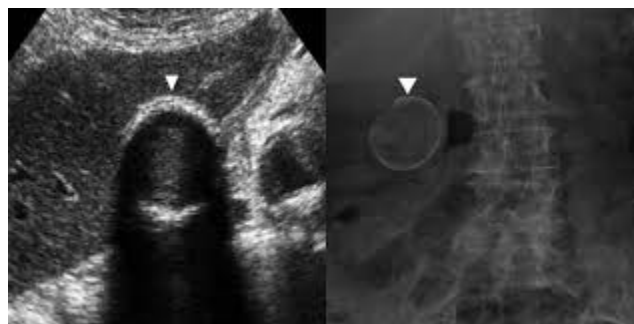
Shows Gall Stone In Plain Radiograph. .(Beliby, 1967)
